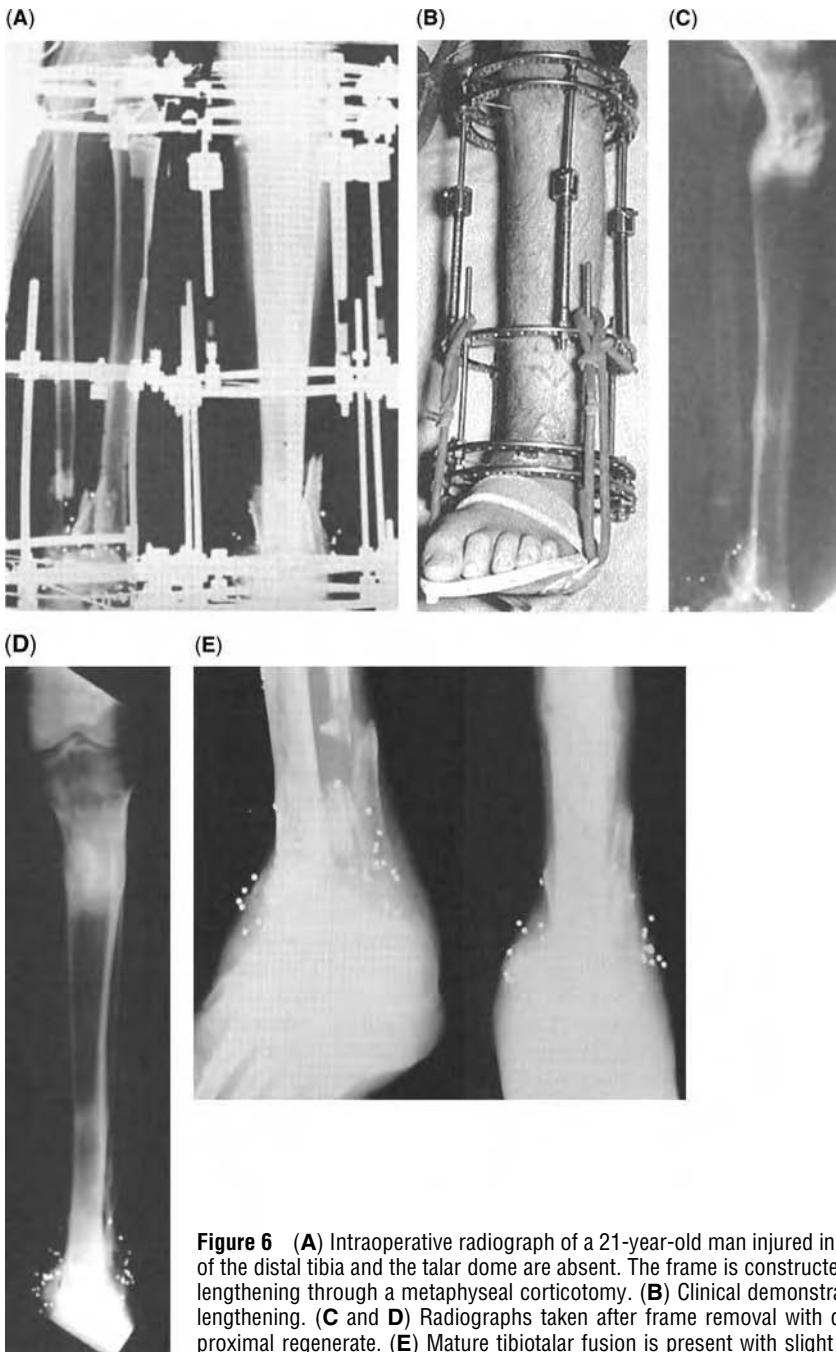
(A) Intraoperative radiograph of a 21-year-old man injured in a hunting accident; 6 cm of the distal tibia and the talar dome are absent. The frame is constructed to allow proximal tibial lengthening through a metaphyseal corticotomy. (B) Clinical demonstration of the frame before lengthening. (C and D) Radiographs taken after frame removal with demonstration of mature proximal regenerate. (E) Mature tibiotalar fusion is present with slight shortening of the fibula.
